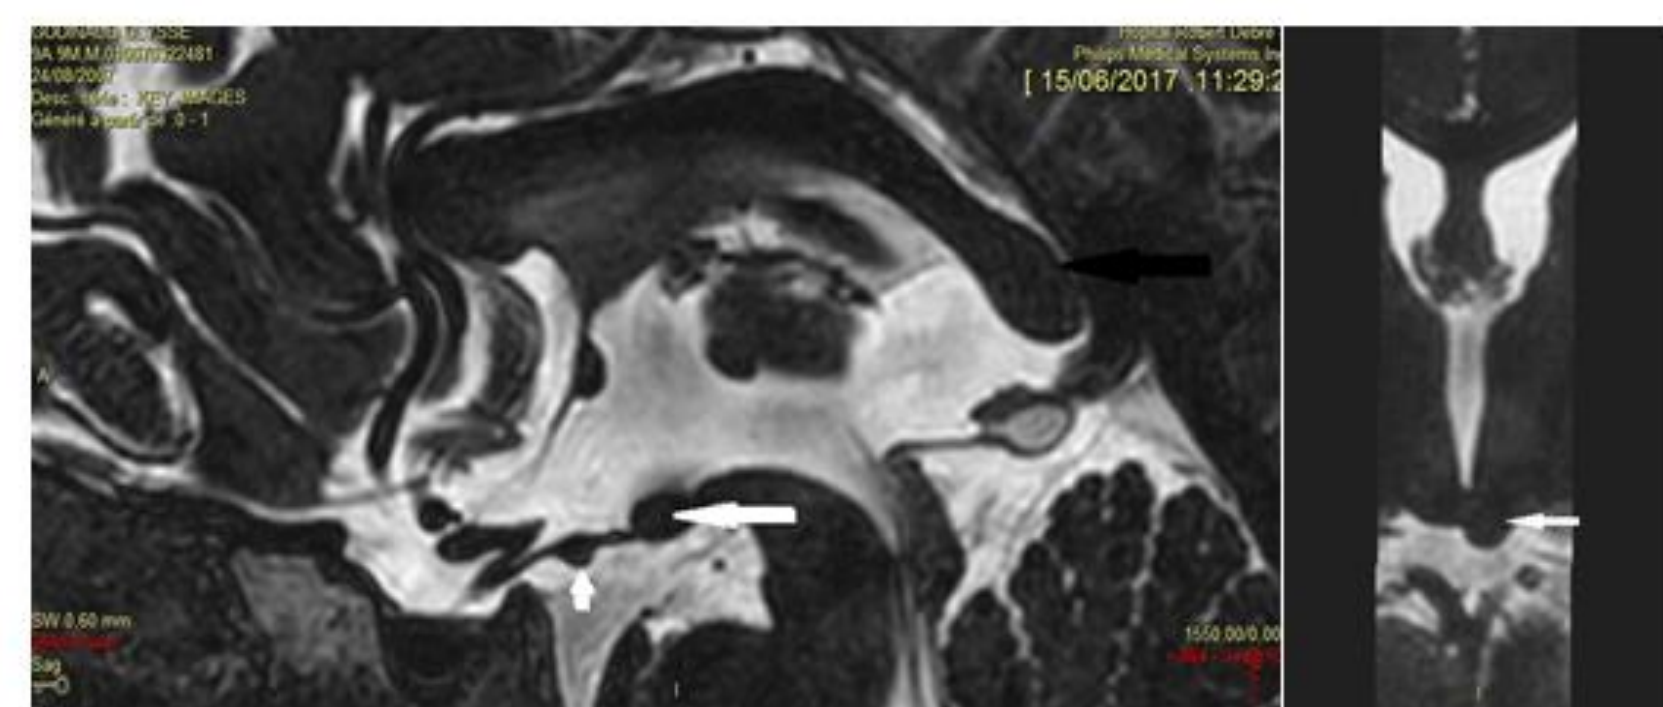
MRI of Patient with Mowat-Wilson syndrome: double hypothalamic hamartomas
